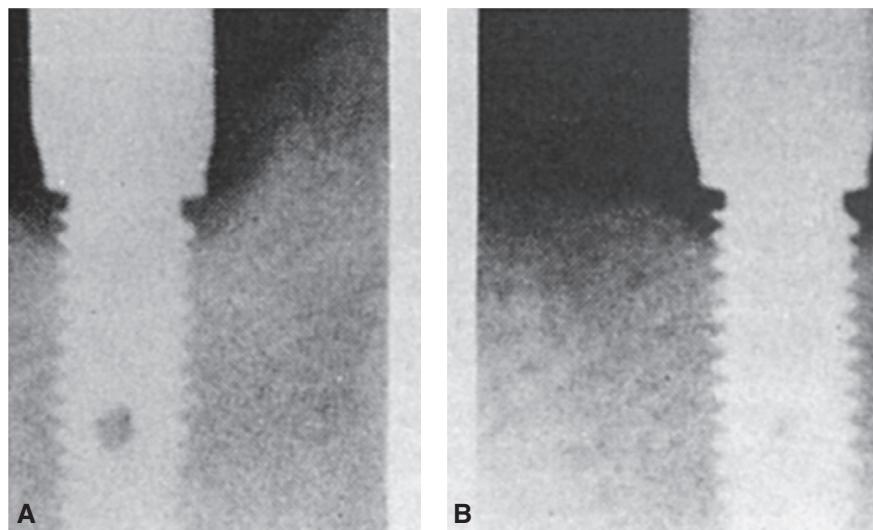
To monitor implant bone loss, radiographs should be obtained once a year. (A) At the time of delivery. (B) At the 1-year follow-up visit.
